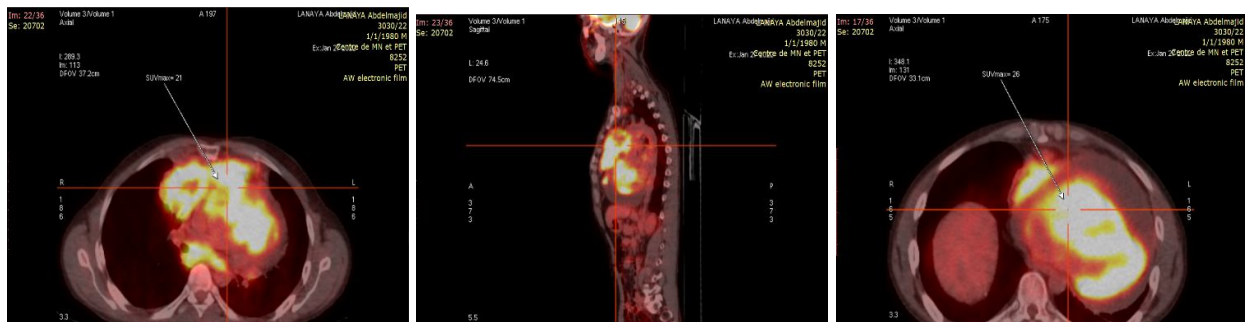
PET-FDG showing lymphomatous dissemination at the mediastinal level: at the level of the known cardiac mass with a diffuse infiltration of the anterior mediastinum and a subcarinal lymph node magna.
